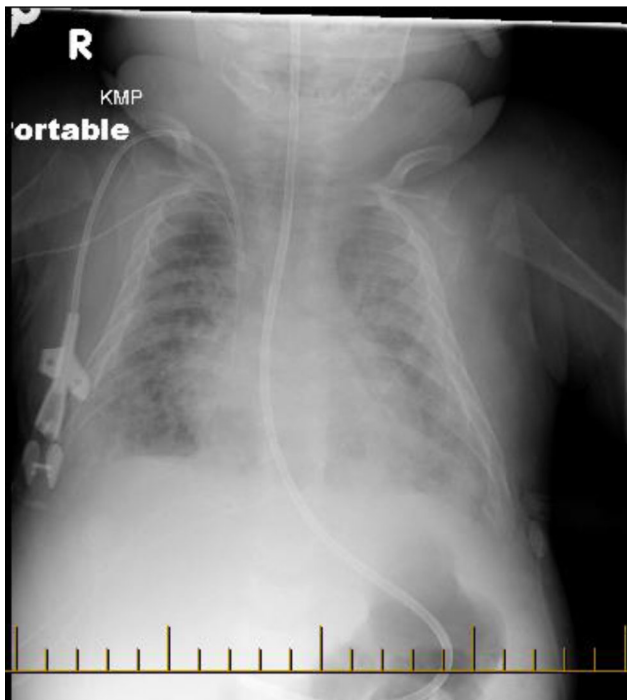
HD 28, Chest X-ray showing diffuse bilateral pulmonary infiltrates.
